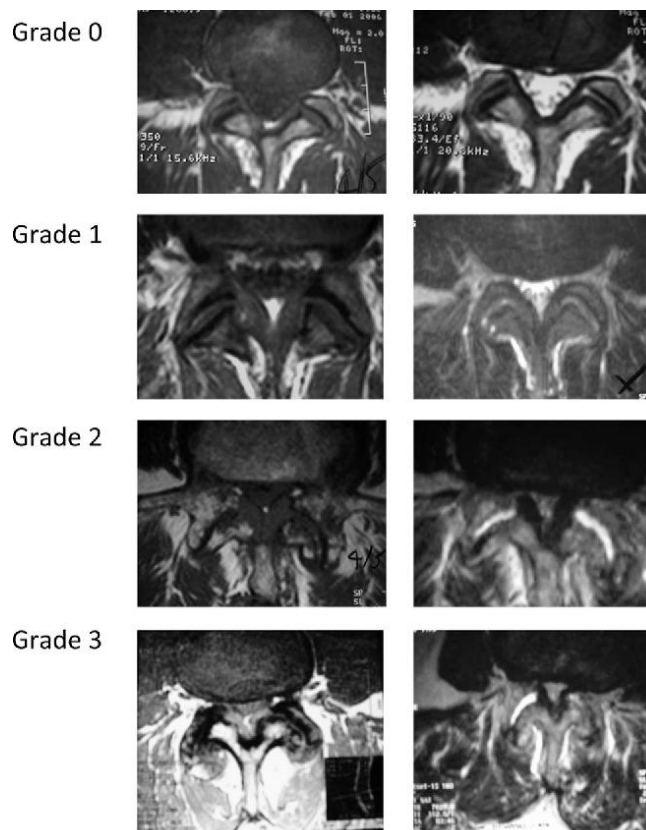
MRI appearance of each grade of lumbar facet arthropathy according to Pathria classification
